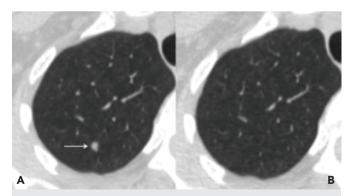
A 61-year-old female who has been followed-up for a 6 mm nodule in the left lower lobe underwent non-contrast control computed tomography imaging, (A) which showed a 5 mm new nodule (arrow) in the right upper lobe. (B) 15 months later, this 5 mm nodule disappeared, thus revealing its benign nature
